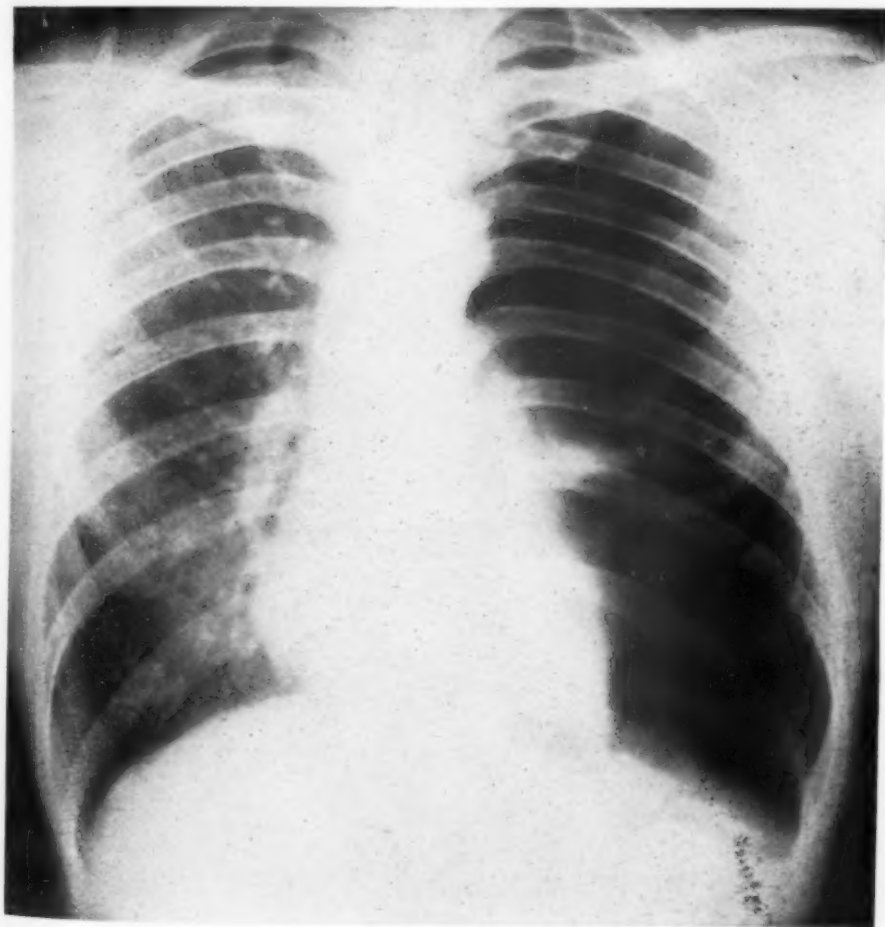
Radiograph of Case No. II at time of pneumothorax.
